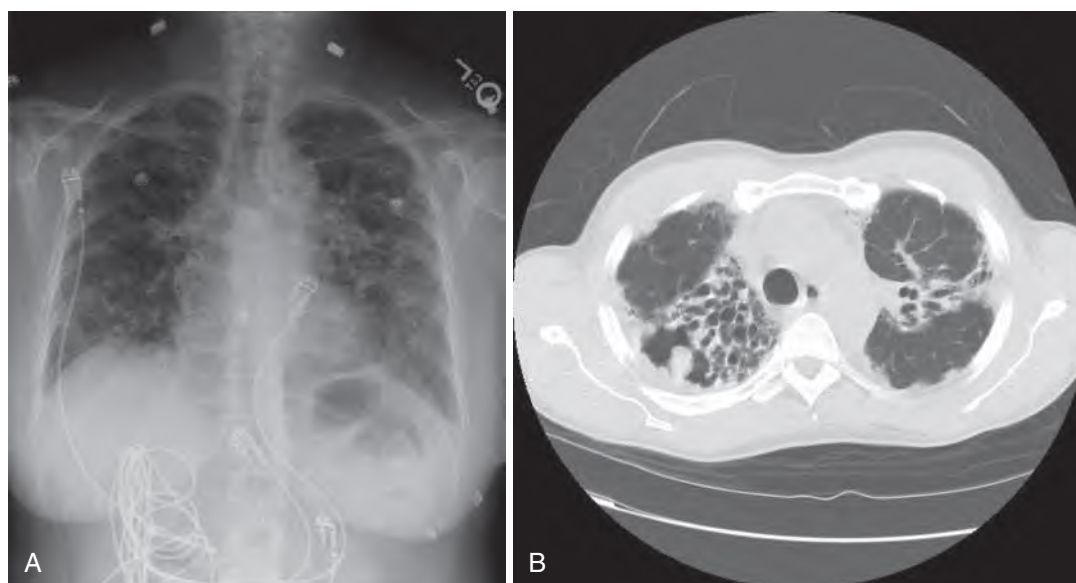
(A) This 45-year-old woman with long-standing pulmonary sarcoidosis has had progressive exertional dyspnea and occasional cough productive of scant hemoptysis. She has received intermittent oral glucocorticosteroids with symptomatic relief but insidious disease progression. (B) A computed tomography scan of this patient reveals extensive fibrocavitary disease with honeycombing and bronchiectasis. There is a pulmonary aspergilloma (mycetoma) in the superior segment of the right lower lobe, noted to be the likely source of hemoptysis.
